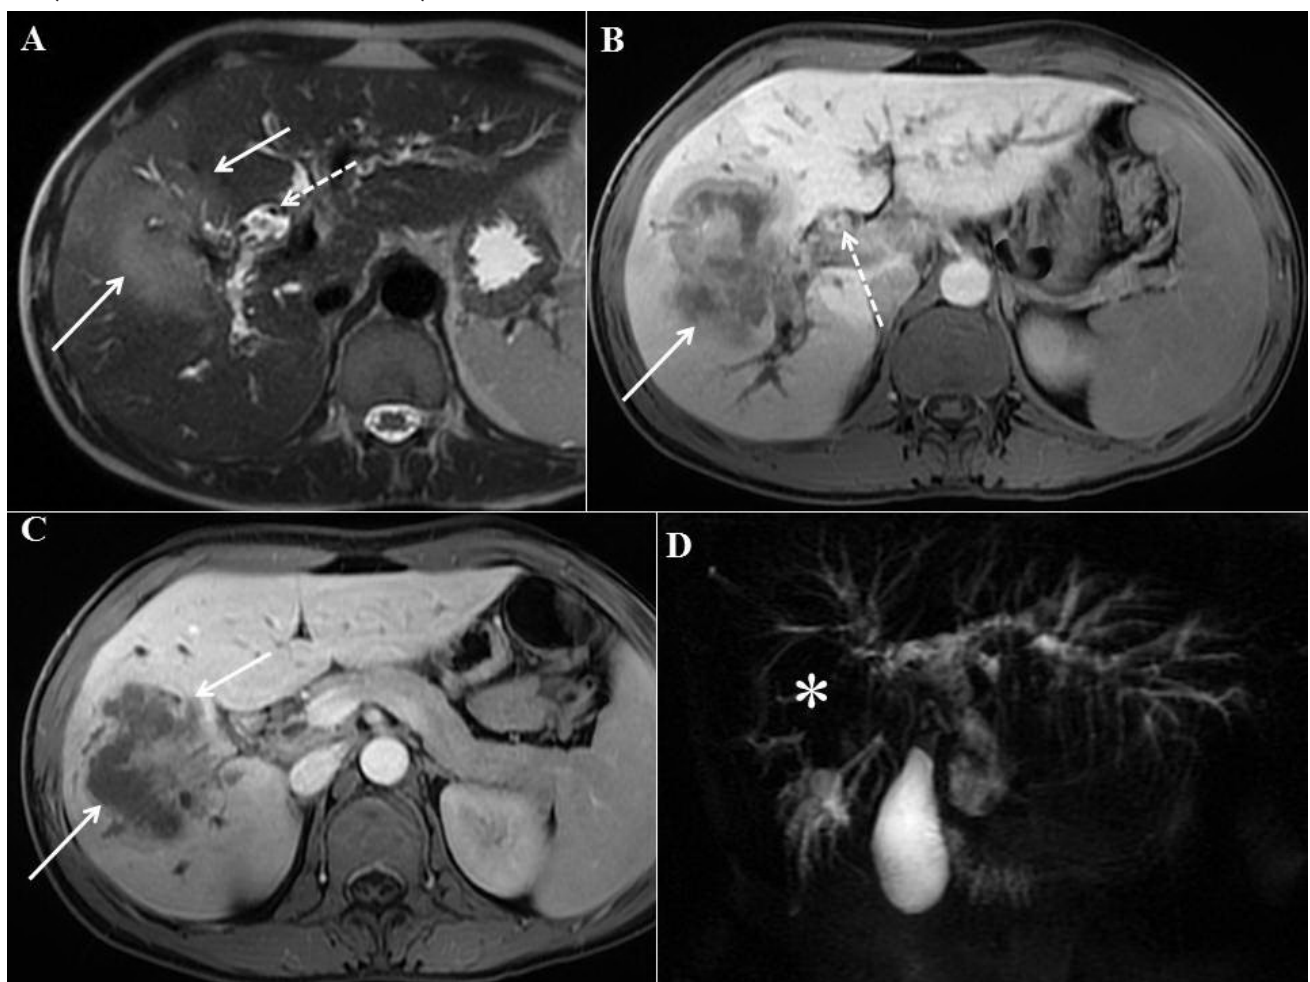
Cholangiocellular carcinoma complicating long-standing primary sclerosing cholangitis in a 52-year-old male patient. (A) An axial T2-weighted image displays a large irregular, moderately hyperintense mass in the right liver (*solid arrows*). Bile ducts are irregularly dilated in both lobes due to primary disease. Multiple intrahepatic calculi are also present (*dotted arrows*). (B) An axial T1-weighted fat-saturated image reveals a hypointense mass with a central necrotic part (*solid arrow*). Intrahepatic calculi are also visible as hyperintense lesions within dilated bile ducts (*dotted arrow*). (C) On the portal-venous phase T1-weighted fat-saturated image, the tumor appears as a hypovascular lesion (*solid arrows*). (D) A thick slab MRCP demonstrates multifocal alternating strictures of intrahepatic bile ducts with loss of bile duct visualization in segment V corresponding to tumor infiltration (*asterisks*).
